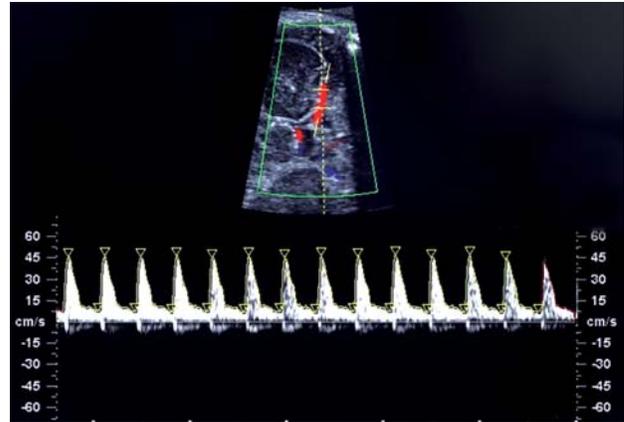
Circulus arteriosus Willisii. Normal ACM spectral Doppler signature with typical high resistance for early 3rd trim
